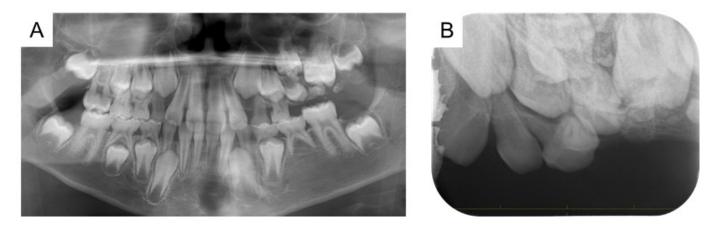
Panoramic and periapical radiographs at 8 years 2 months of age showing calcified tissue resembling odontomas. (A) Panoramic radiograph. (B) Periapical radiograph around the maxillary left molars.
